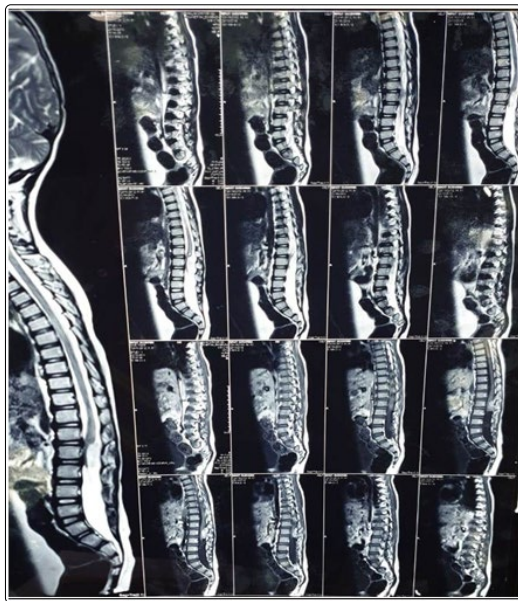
T2 MRI Saggital sections showing hyperintense lesion located in L1 and L2 region intradural-extramedullary lesion
